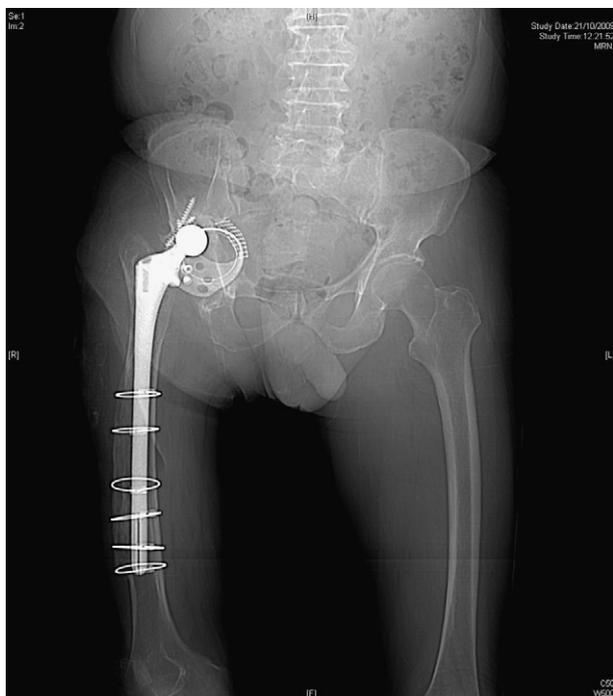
Radiograph showing the acetabulum osteolysis and protrusion of the acetabulum cup in October 2009.
